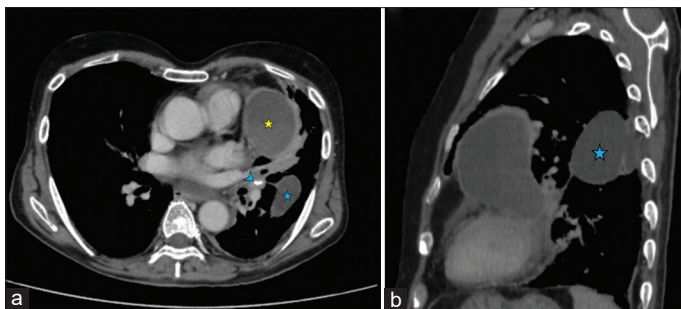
(a and b) Axial and sagittal sections of contrast-enhanced computed tomography thorax showing peripherally enhancing cystic lesion abutting the left heart border (yellow star). Loculated fluid collection in the left oblique fissure without post-contrast enhancement (blue star). Calcified left hilar lymph node (blue arrowhead)
